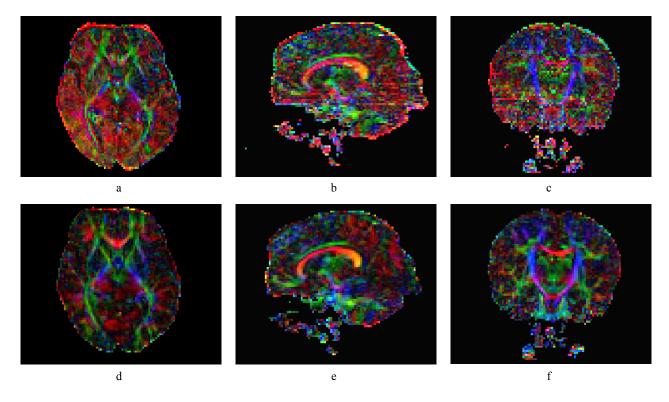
Orthogonal views of the color coded FA map calculated from a test DWI data set before (a: axial, b: sagittal, c: coronal) and after (d: axial, e: sagittal, f: coronal) QC using DTIPrep.
